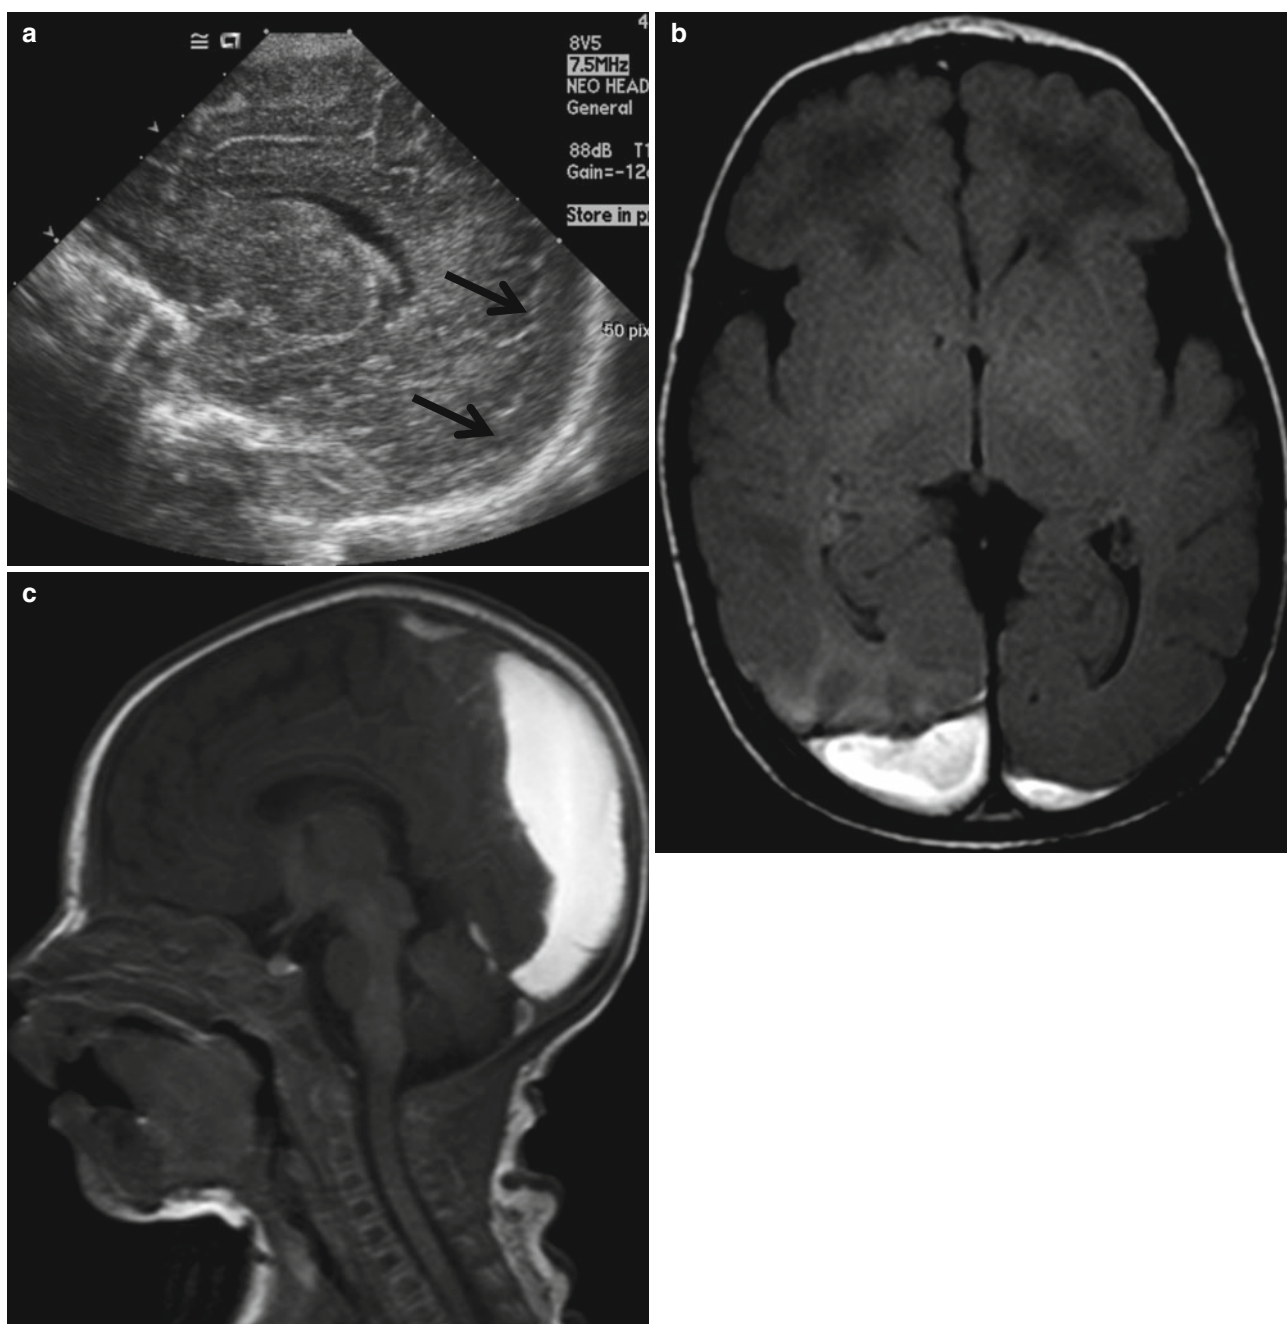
Large amount of SDH. (a) Parasagittal sonogram shows isoechogenic extraaxial collection (*arrows*). (b, c) FLAIR axial and T1-weighted sagittal images demonstrate bilateral hyperintense SDH
